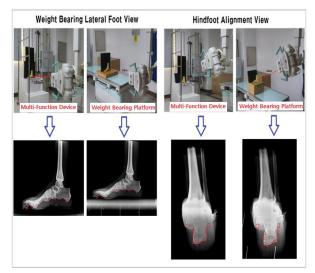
X-ray images of MFD and WBPs.
